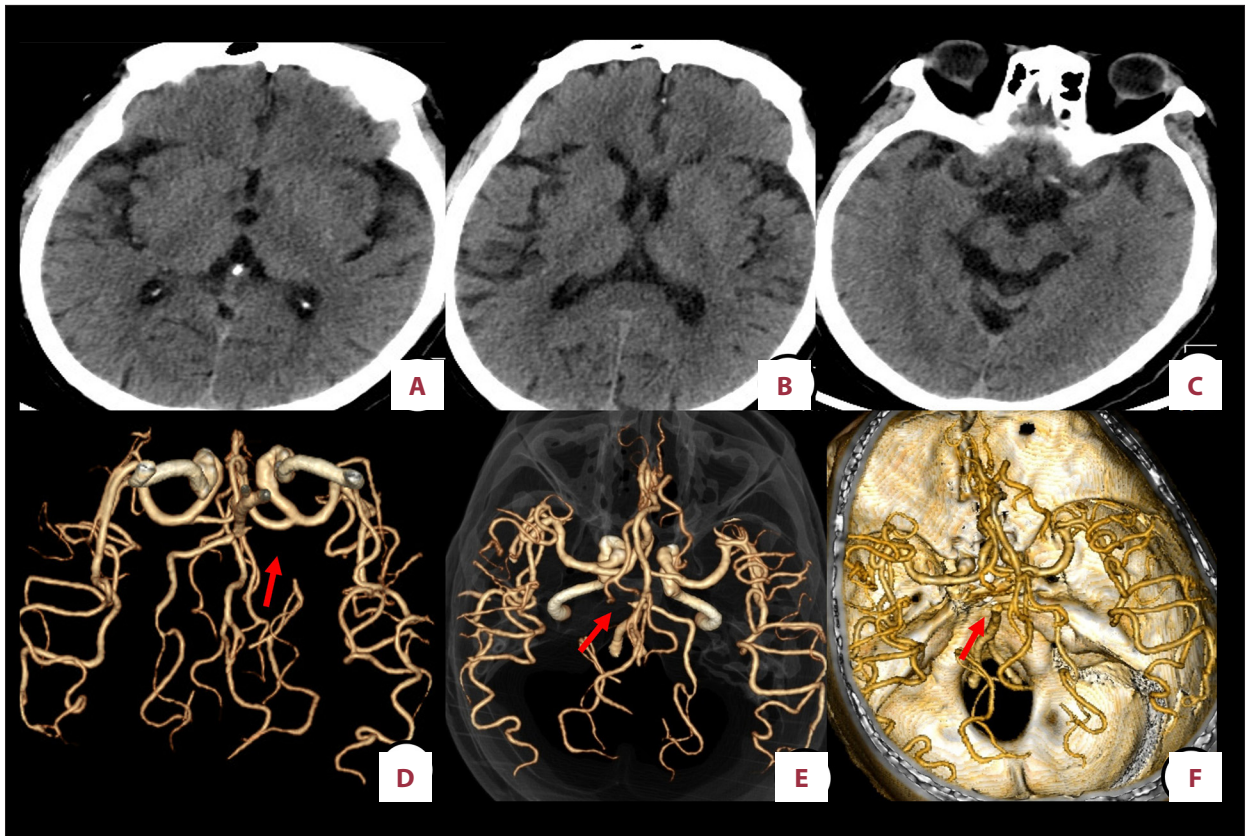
(A-C) No obvious abnormal lesions were found in the bilateral thalami and midbrain. (D-F) Computed tomography angiography reveals severe stenosis to occlusion in the P1 segment of the left posterior cerebral artery.
